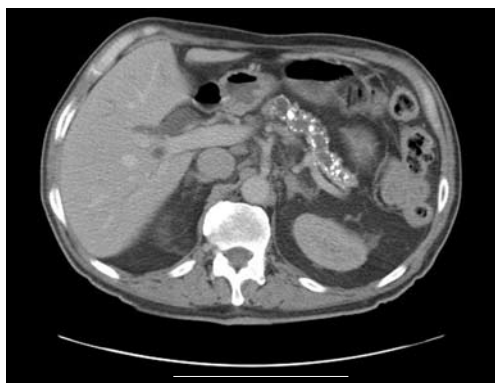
Abdominal computed tomography image showing gross pancreatic duct dilatation and extensive pancreatic calcification as well as bile duct dilatation. No distinct mass was seen.
